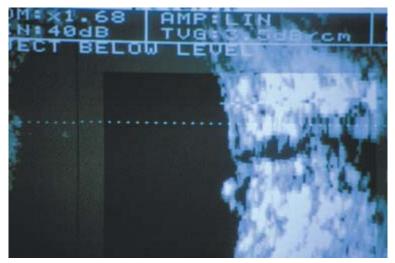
A-B ultrasonography. Cystoid macular oedema.
